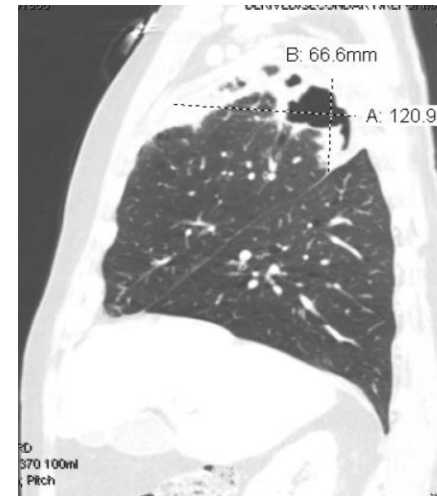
Image (b) Sagittal CT – Imaging of chest demonstrating focal cavitary lesion.
